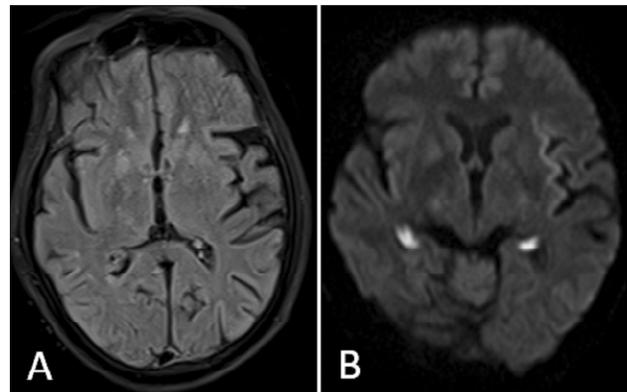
A 35-year-old male brought to the hospital with complaints of seizure, cerebrovascular accident, and unconsciousness for one day. The MRI scan demonstrates acute ischemic changes, which are (A) Axial FLAIR image reveals high signal intensities bilateral hippocampi, bilateral subcortical white matter show restricted diffusion on the diffusion-weighted image (B).
